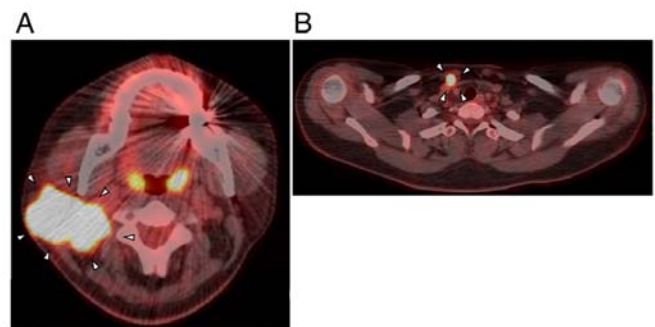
FDG positron emission tomography/computed tomography shows a high uptake of FDG. (A) Tumour in the right parotid, SUV maximum is 21. Arrowheads indicate the tumour. (B) Lymph node in the right lower cervical region, SUV maximum is 13.9. Arrowheads indicate the lymph node. FDG, ^{18}F -fludeoxyglucose; SUV, standardised uptake value.
